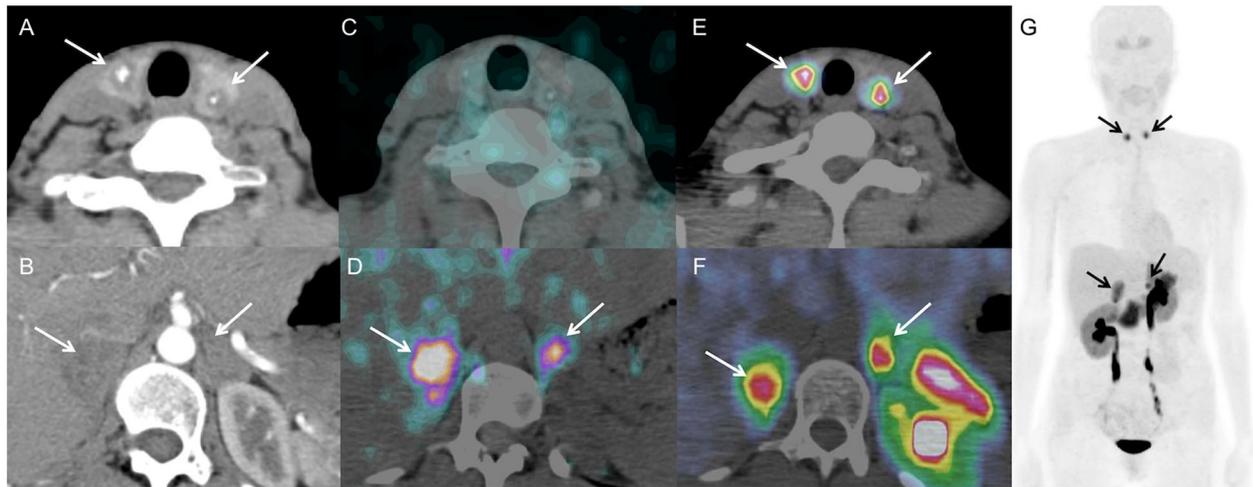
Results of primary staging morpho-functional imaging in a MEN-2A patient with synchronous bilateral pheochromocytoma and bilobar medullary thyroid carcinoma (arrows). a Cervical unenhanced CT shows bilobar thyroid nodules with central calcification. b Arterial phase of contrast-enhanced abdominal CT demonstrates bilateral
